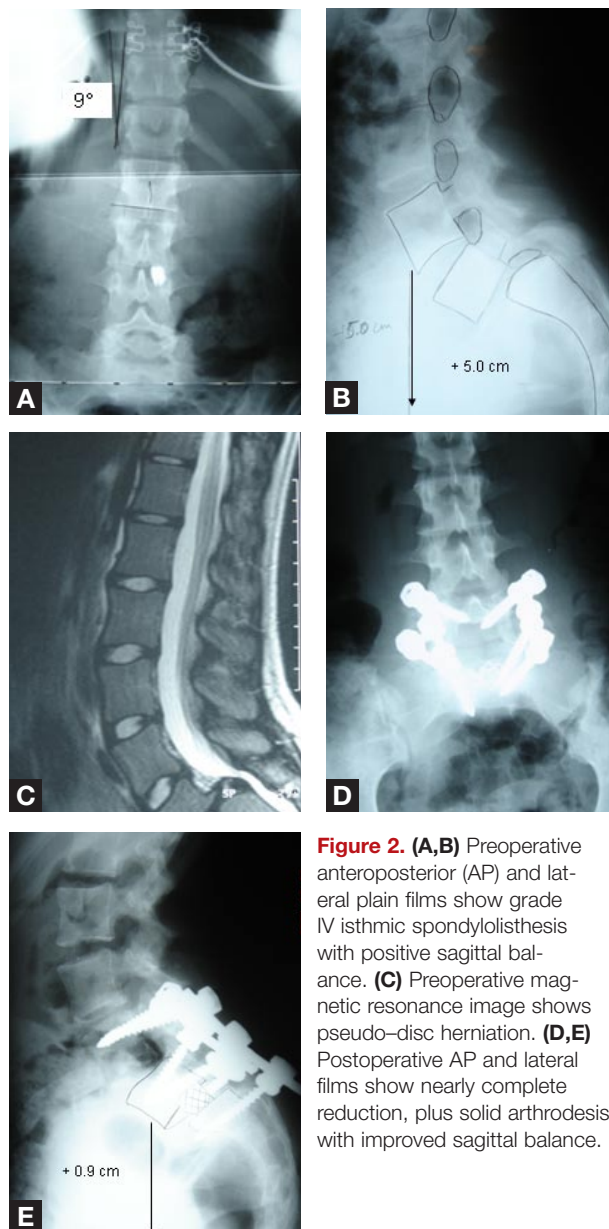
(A,B) Preoperative anteroposterior (AP) and lateral plain films show grade IV isthmic spondylolisthesis with positive sagittal balance. (C) Preoperative magnetic resonance image shows pseudo-disc herniation. (D,E) Postoperative AP and lateral films show nearly complete reduction, plus solid arthrodesis with improved sagittal balance.
